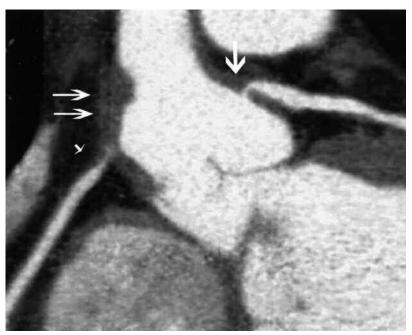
Coronary artery CT angiogram with multiplanar reformation. Critical and severe stenosis is seen at the ostium of the right coronary artery (arrowhead) and left main coronary artery (long arrow) respectively. There is irregular, asymmetric wall thickening of the aortic root due to aortitis (double arrow) that extends to involve the ostia of both coronary arteries.
